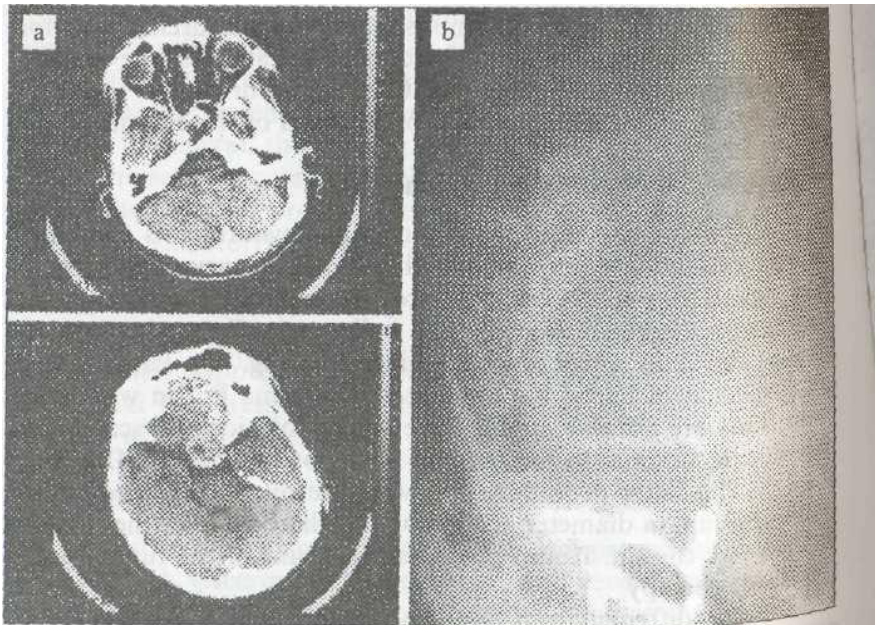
Adenoma of the hypophysis: a) CT, b) angiography
